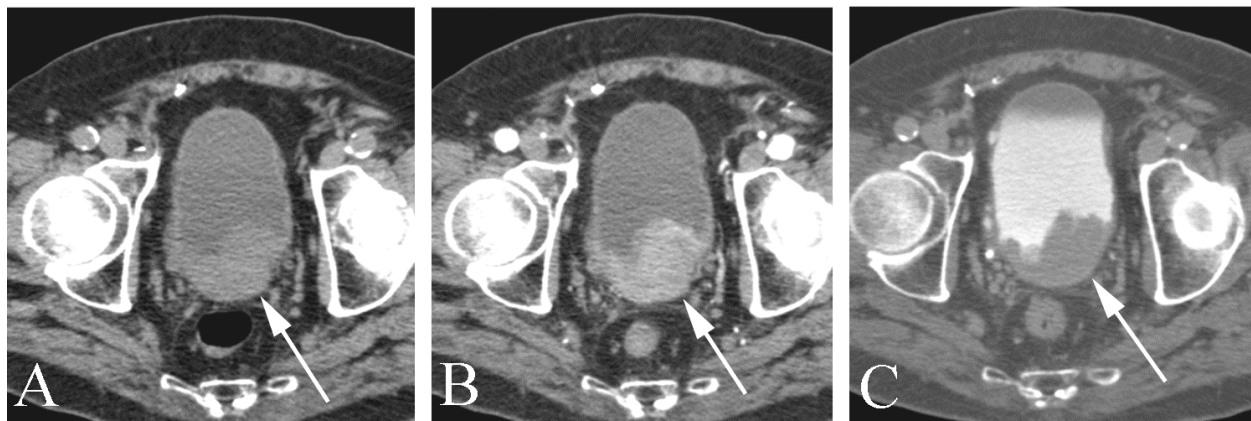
Transitional cell cancer of the bladder in a 79 year old man with hematuria. A. Unenhanced CT shows a subtle filling defect within the bladder (arrow). B. The portal venous phase image (taken two minutes following contrast injection) shows a contrast-enhancing lesion (arrow). C. On the delayed image (taken 10 minutes after contrast injection) the filling defect (arrow) is much more conspicuous against the background of the opacified urine. Less dense, unopacified urine is seen along the anterior bladder.
